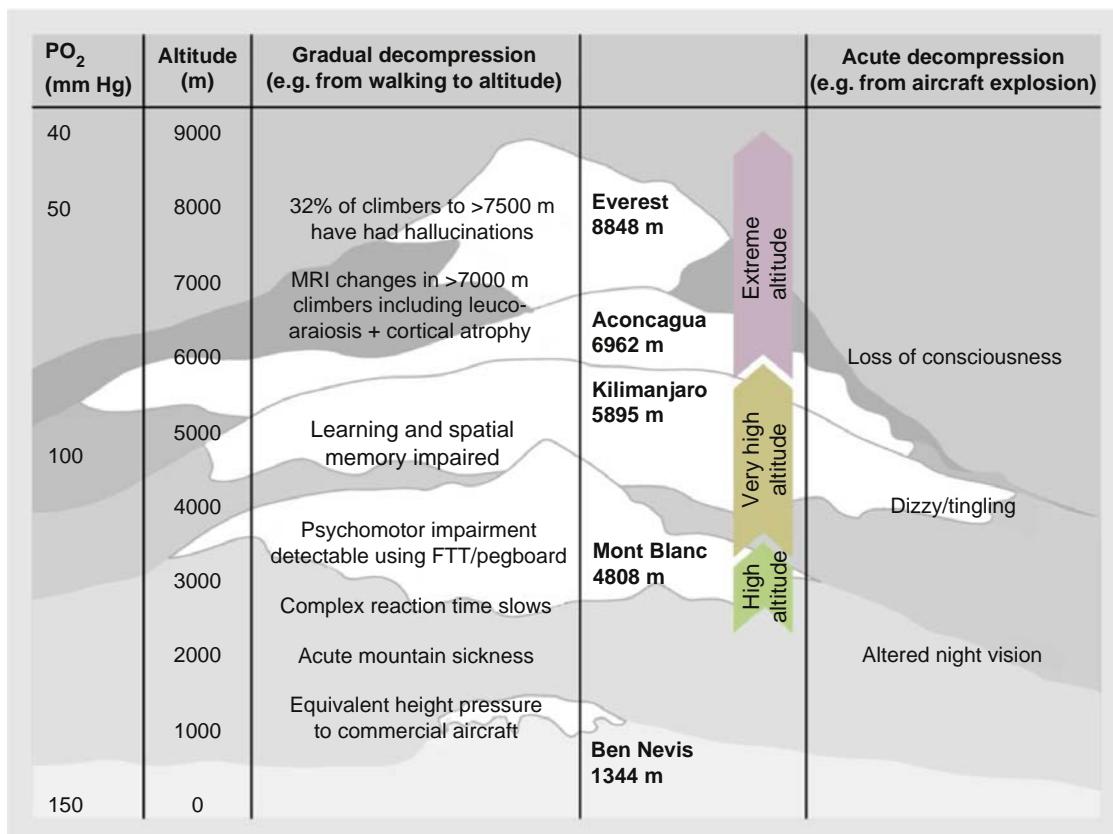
The symptoms and clinical effects associated with the nonlinear decrease in barometric pressure at increasing altitude. *MRI*, magnetic resonance imaging. (From Wilson MH, Newman S, Imray CH. The cerebral effects of ascent to high altitude. *Lancet Neurol*. 2009;8:175–191.)
